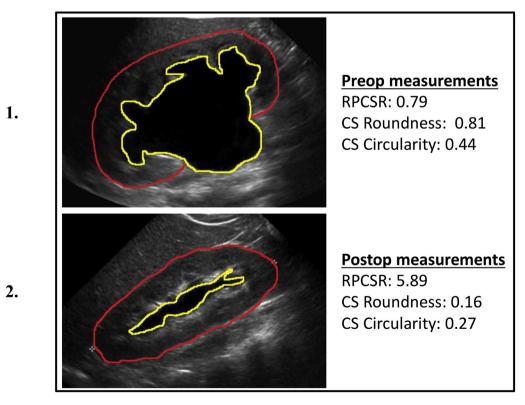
Imaging. Ultrasound of a single kidney undergoing successful pyeloplasty with improved post-operative MAG3 drainage curve. Pre-operative (1.) and post-operative (2.) images are depicted. Total renal area and renal collecting system area highlighted in software. Image demarcations are used as inputs to calculate RPCSR, circularity, and roundness.
